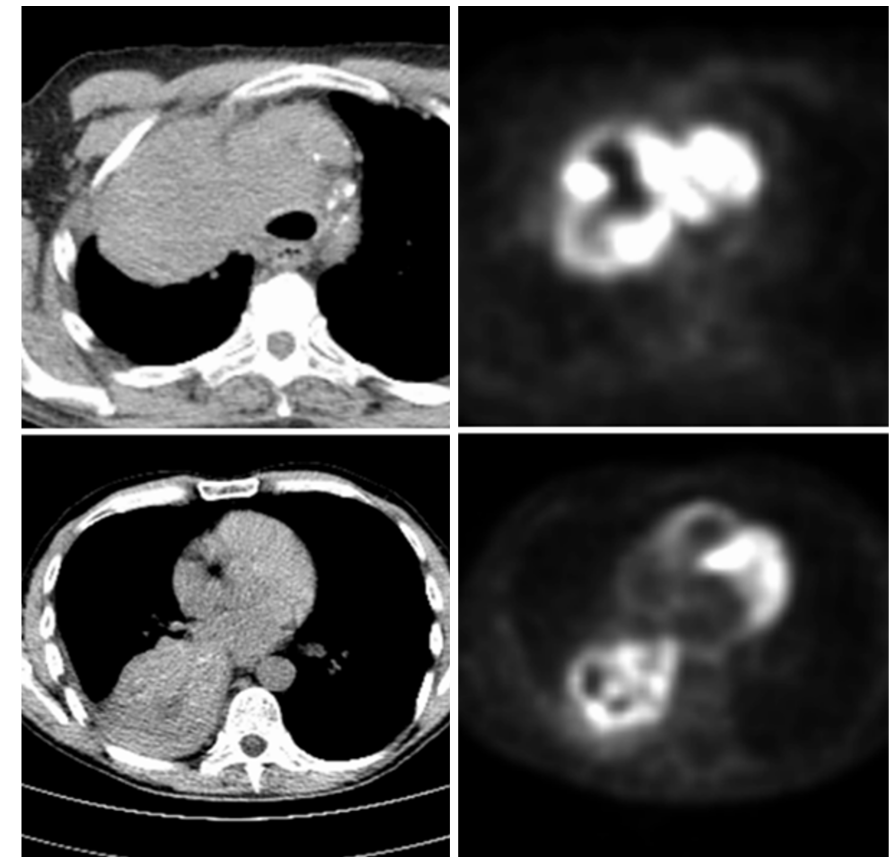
Axial view of two primary lung tumors visualized on registered images from CT (left) and PET (right). On the upper CT slice, the tumor looks like a solid homogeneous mass, but in contrast shows a highly heterogeneous pattern on PET. The CT slice on the bottom does show small photopenic areas centrally located in the tumor, however the extent of this heterogeneity is underestimated in CT when looking at PET.
